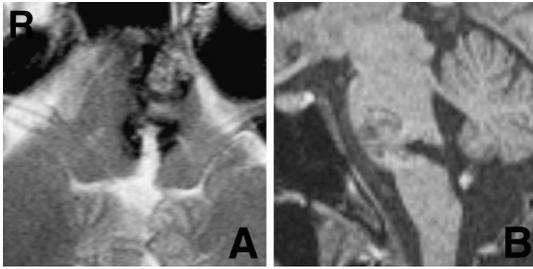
A: Axial T₂-weighted magnetic resonance (MR) image at 8 days after first resection showing complete resection of the pontine tegmentum cavernoma and the remaining ventral pontine cavernoma. B: Sagittal T₁-weighted MR image using magnetization-prepared rapid acquisition gradient echo demonstrating that the remaining cavernoma adjacent to the rostral side in the removal cavity of resected cavernoma was aligned along the direction of the trans-fourth ventricular floor approach.
